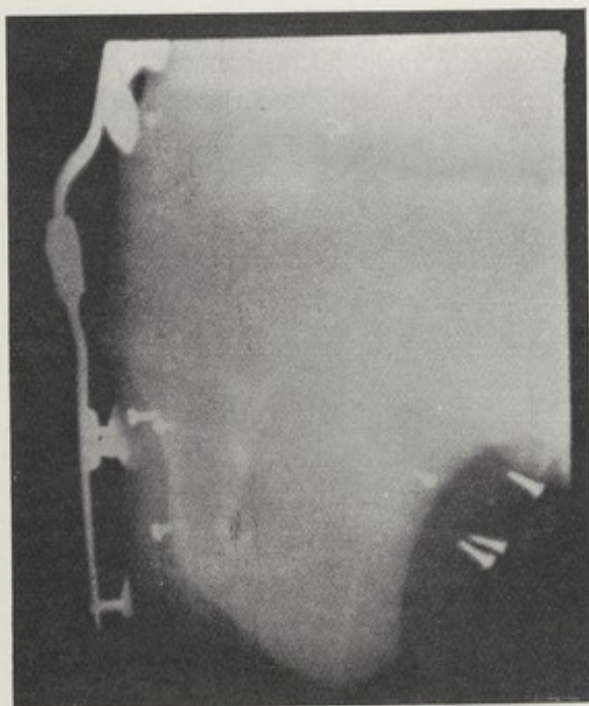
X-RAY PICTURE OF A SHORT THIGH STUMP UNDER SIMILAR CONDITIONS TO THE PRECEDING.
